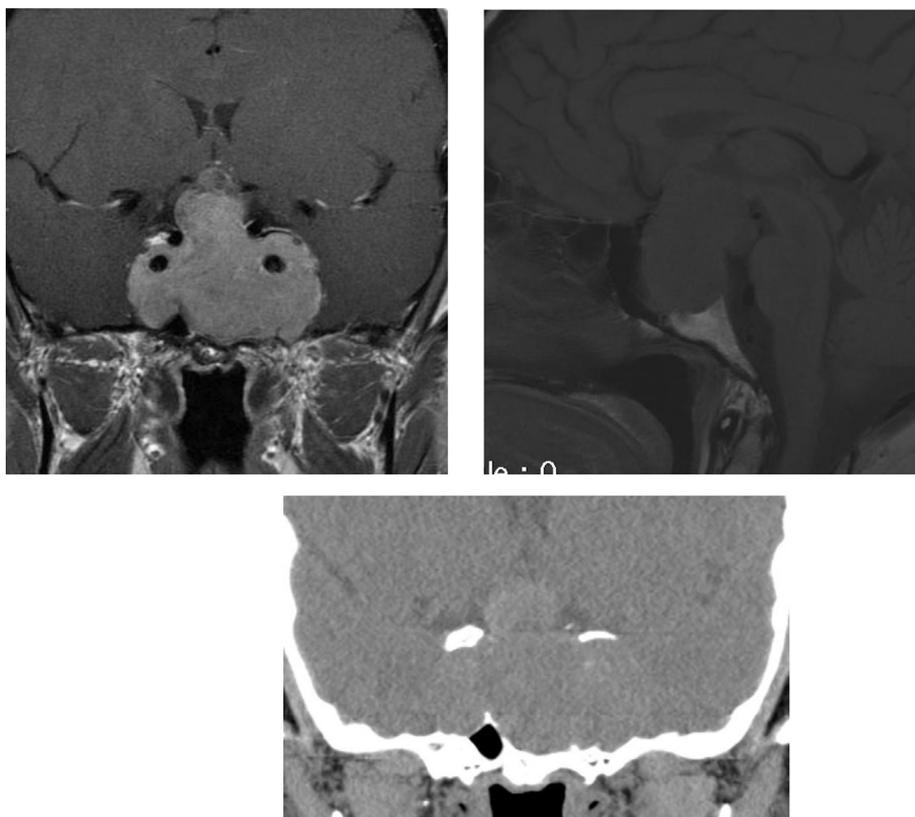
Giant macroprolactinoma in a 35 y-old male patient. T1-weighted MRI coronal section after gadolinium injection and sagittal section (upper panels); CT scan, coronal section showing erosion of the skull base by the macroprolactinoma (lower panel) (reproduced by permission from ref [2]).
